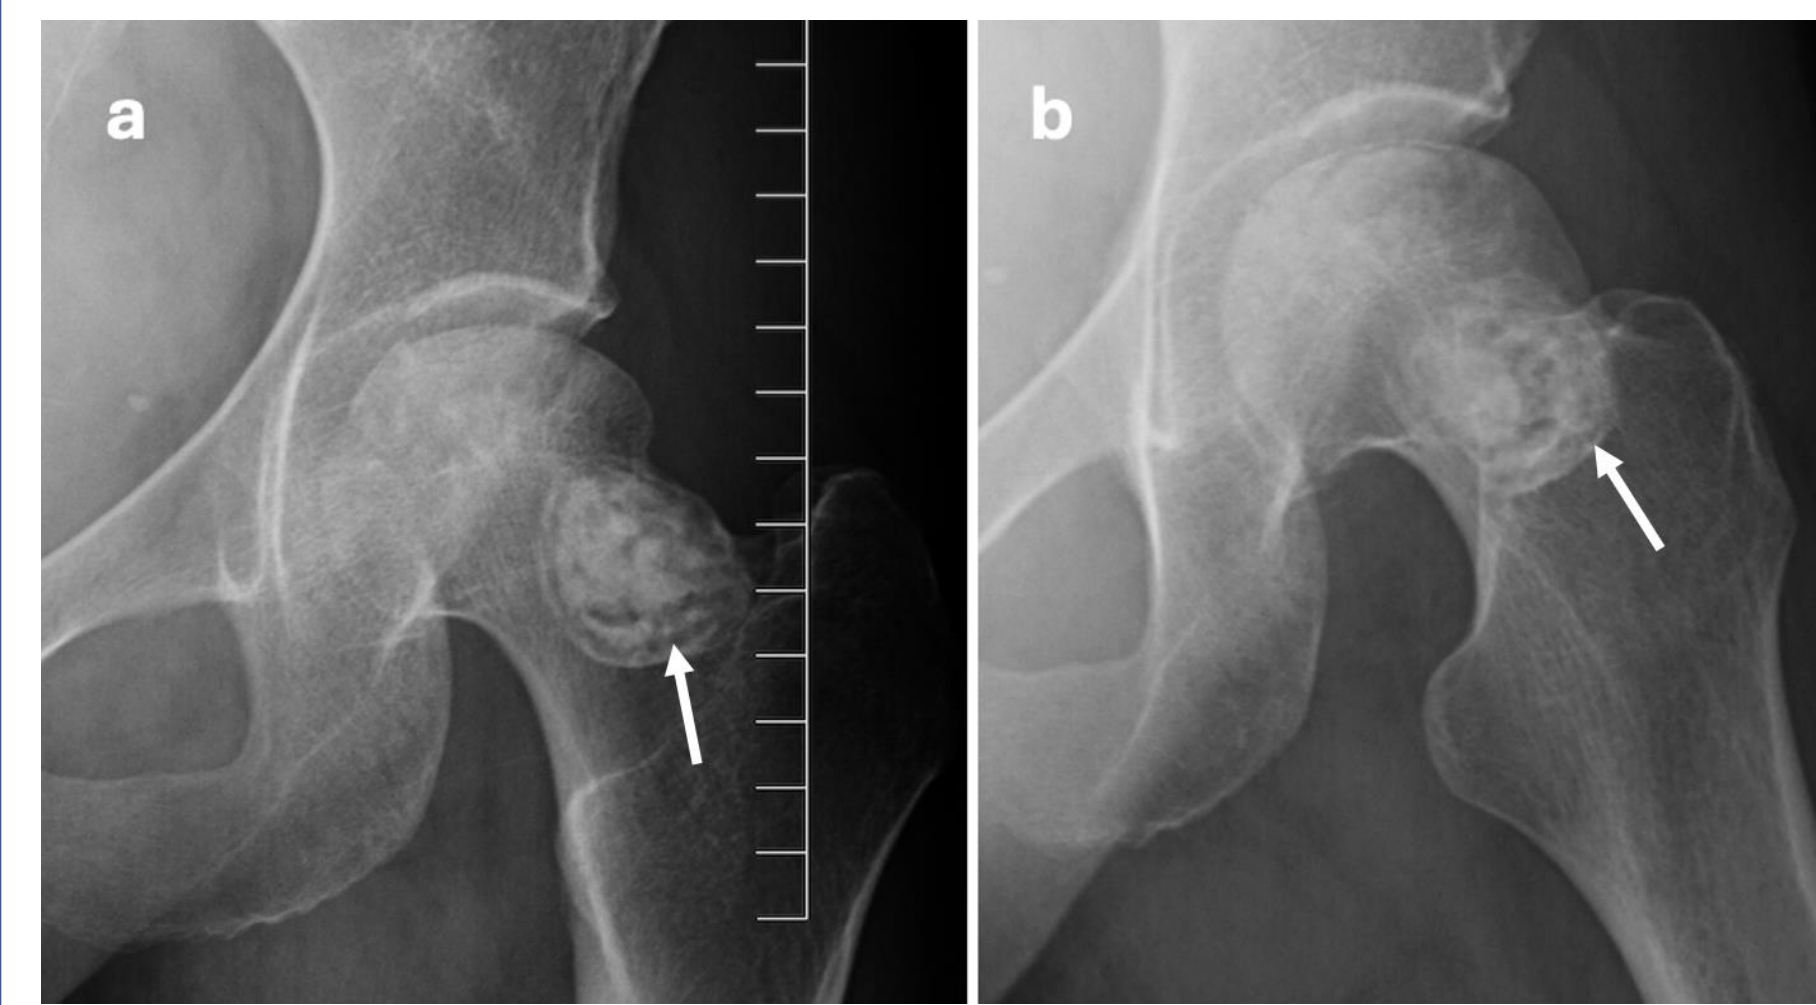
Anteroposterior (a) and lateral (b) radiographs of the left hip reveal lucency in the superior femoral head accompanied by cortical irregularity, as well as a 3.6 cm sclerotic lesion in the femoral neck (white arrows).
